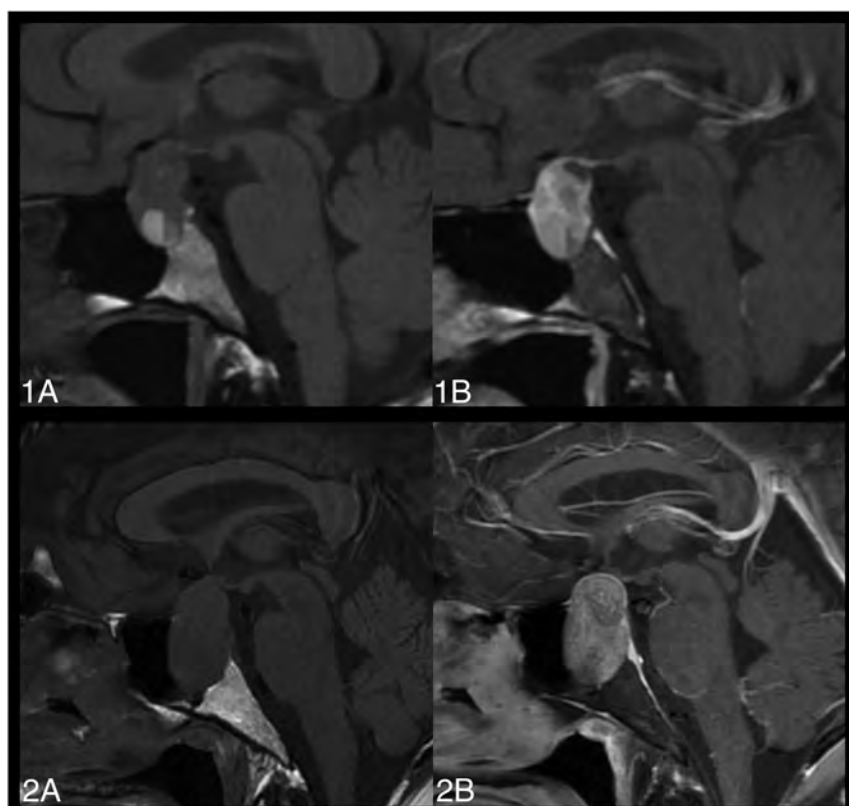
MR images of 2 patients with large pituitary adenomas demonstrate the typical nonenhancing basisphenoid bone marrow. Precontrast (1A/2A) and fat-saturated postcontrast (1B/2B), sagittal T1-weighted images without basisphenoid bone marrow enhancement. Both patients have type 2 pneumatization of the sella.
